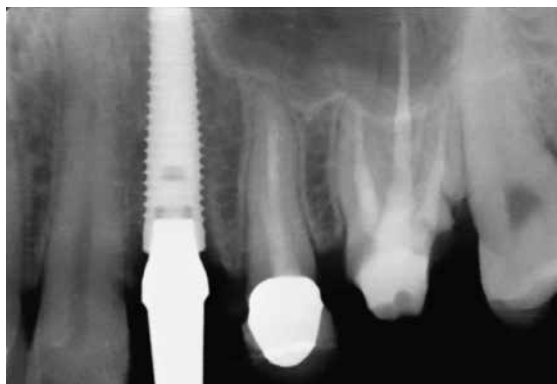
Periapical radiograph immediately after implant placement.
